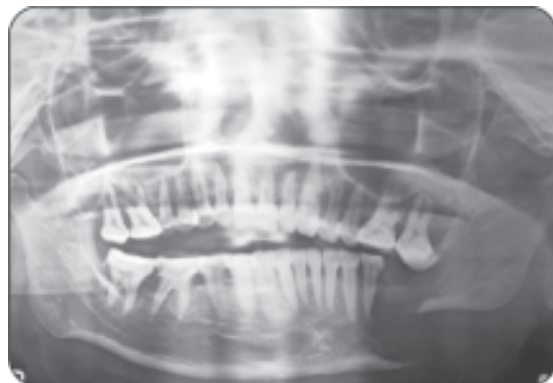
Radiograph of squamous cell carcinoma
